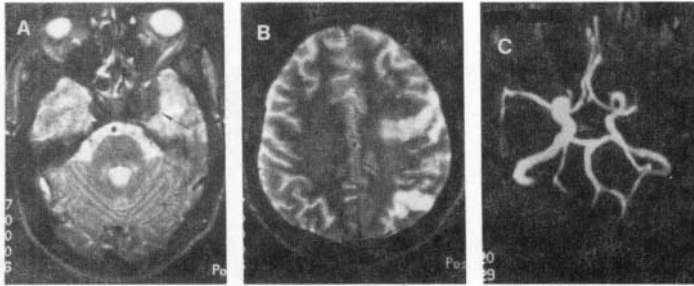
Aspergillosis with major vascular territory infarction. T2-weighted axial image (a) at the level of pons shows a hypointense area (arrow) in the left parasellar region with hyperintensity in the adjoining left temporal lobe. T2-weighted axial image (b) at the supraventricular level shows evidence of hyperintense areas in the frontal and parietal lobes consistent with left middle cerebral artery infarct. MR angiogram (c) shows occlusion of the left middle cerebral artery. The culture from the mass grew *Aspergillus flavus*.
